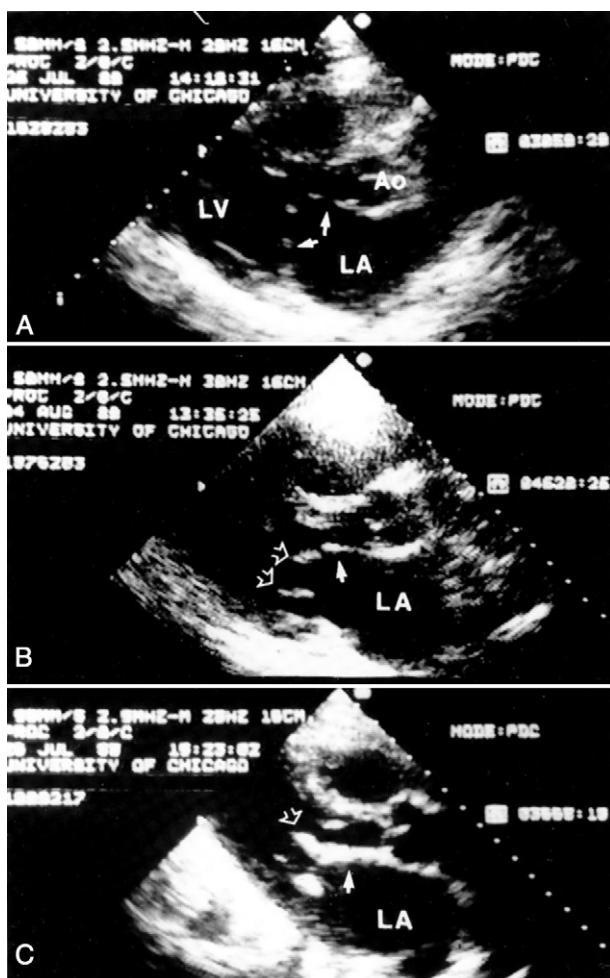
A, Long-axis two-dimensional echocardiographic image from an ideal candidate for mitral commissurotomy. The solid arrows show the thin, domed leaflets. The mitral apparatus is not visible in the left ventricle, signifying its freedom from significant thickening. B, Typical valve replacement candidate. The solid arrow points at a thickened and calcified anterior mitral leaflet. The open arrows show the thickened submitral apparatus. These patients have echocardiographic scores between 8 and 12 and are reasonable candidates for percutaneous transvenous mitral commissurotomy, although they may have poorer long-term freedom from mitral valve replacement. C, Elderly patient, not a likely candidate for surgical therapy of any kind. This patient was an 88-year-old woman. The solid arrow shows a densely calcified, thickened, and rigid anterior mitral leaflet. The open arrow points to the similarly thickened and calcified mitral apparatus. Balloon dilatation may be accomplished successfully in these patients but with acute results that are not as good as those in patients with less deformed valves. The long-term event-free outcome for these patients is poor. (From Feldman T, Carroll JD. Cardiac catheterization, balloon angioplasty, and percutaneous valvuloplasty. In Hall JB, Schmidt GA, Wood LDH, eds. *Principles of critical care*. New York: McGraw-Hill, 1992:343-360.)
